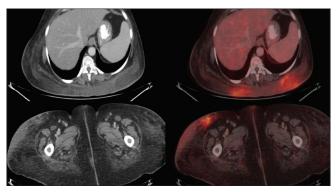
Axial images showing subcutaneous thickening and FDG uptake
